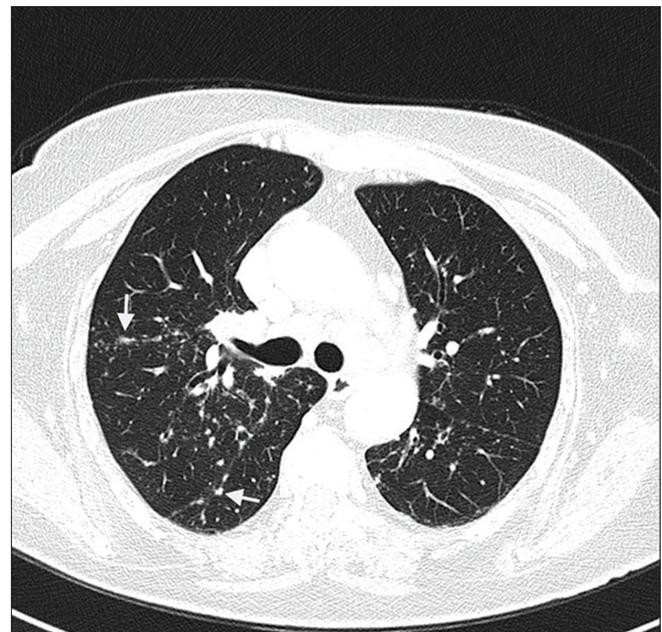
Multiple small sub-pleural, peri-bronchovascular and centrilobular nodules (arrows) in the lungs with multiple mediastinal lymphadenopathies (CT scan)
